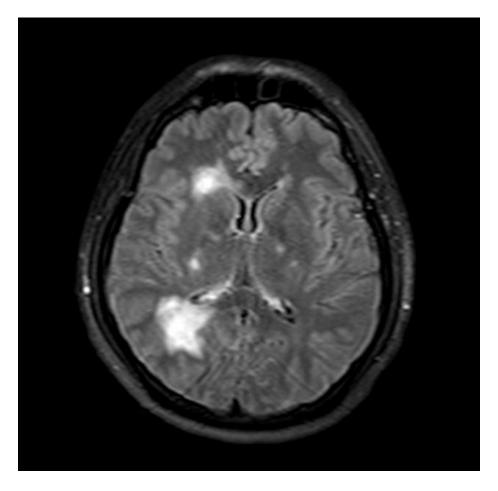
The MRI picture above is of a brain with acute disseminated encephalomyelitis
